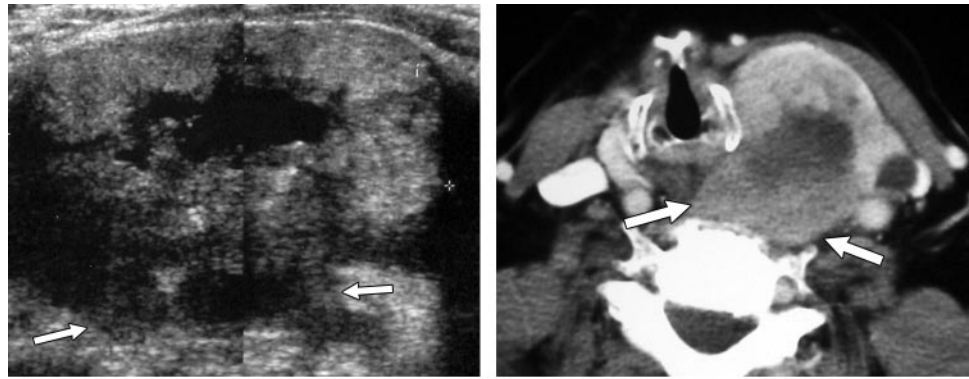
Anaplastic thyroid carcinoma in an 84-year-old woman. (a) Transverse sonogram of the left lobe of the thyroid shows an advanced tumor with infiltrative posterior margins (arrows) and invasion of prevertebral muscle. (b) Axial contrast-enhanced CT image shows a large tumor that has invaded the prevertebral muscle (arrows).
